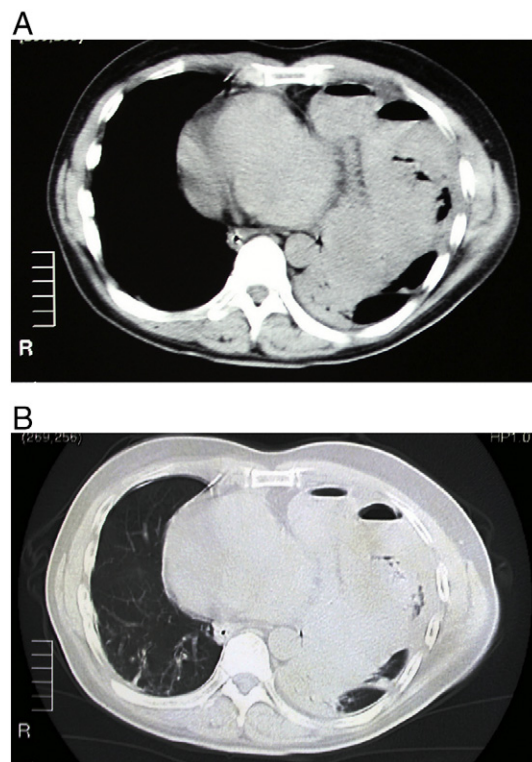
A Chest CT scan showed air-filled bowel in the left thorax, accompanied by pleural effusion. B Chest CT scan showed intestinal inflation in the left chest, accompanied by pulmonary atelectasis.
